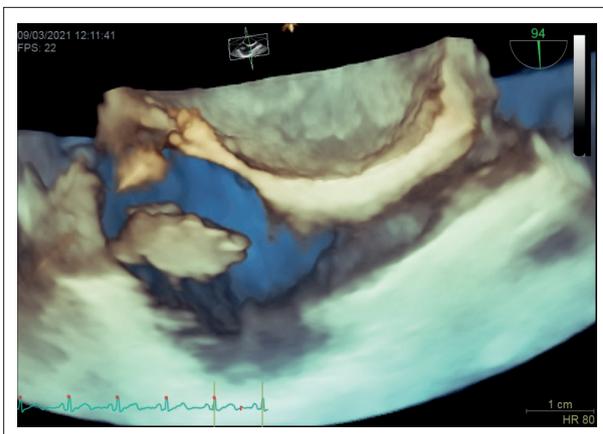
Transesophageal echocardiography showing the right atrial mass.
